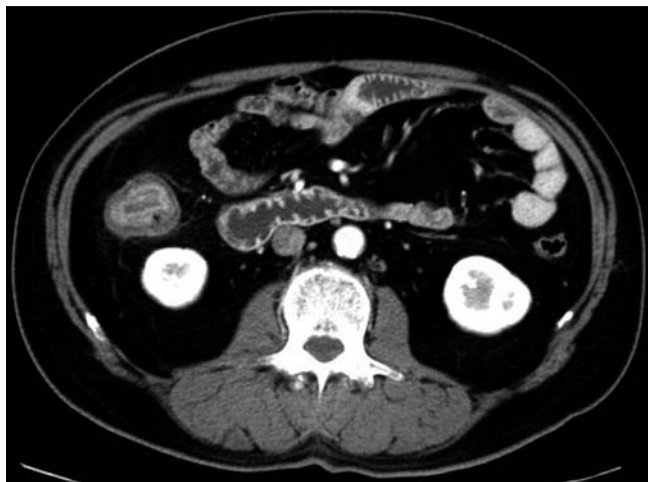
Contrast-enhanced computed tomography shows thickening of the wall of the ascending colon in a 52-year-old man admitted for treatment of diabetes mellitus.
